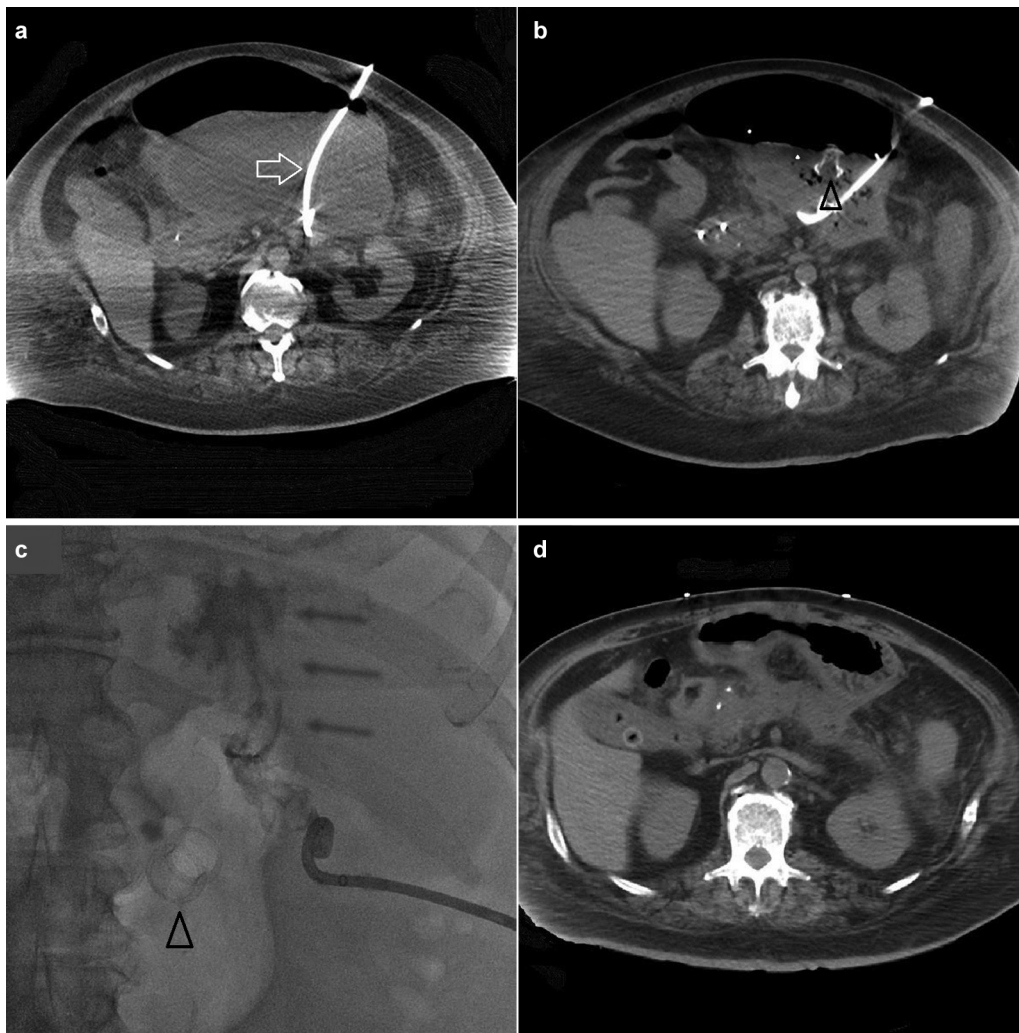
(a) Percutaneous transgastric drainage (arrow) of an infected APFC at 3 weeks' duration. (b) Addition of an endoscopic LAMS after 4 weeks (arrowhead), with the collection now considered a pseudocyst with a mature wall. (c) Tube check of IR drain demonstrating retraction of the catheter into the stomach with contrast outlining rugae (line arrows) and LAMS appearance under fluoroscopy (arrowhead). (d) CT appearance after LAMS removal.
